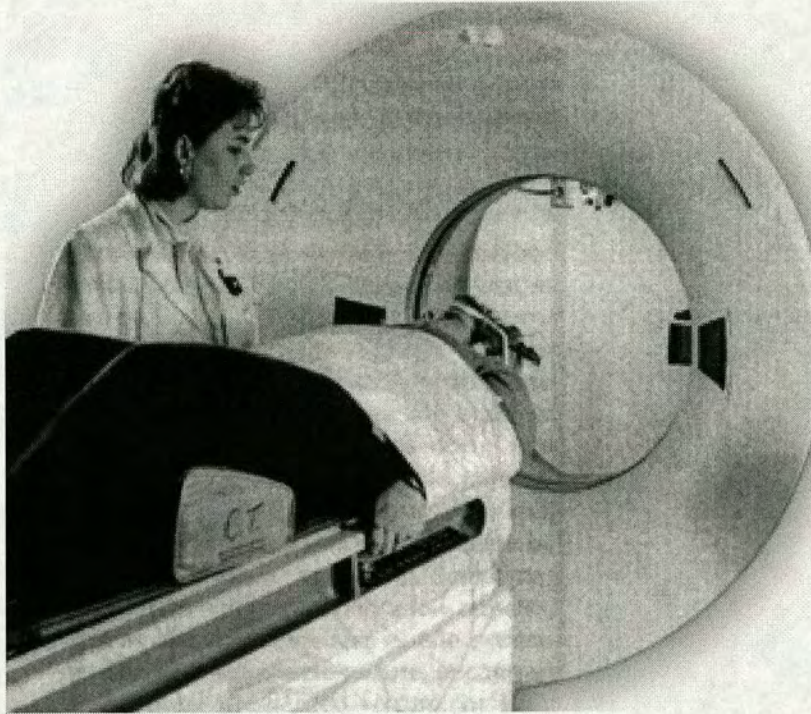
A patient being prepared to enter a typical full-size MRI scanner prior to being imaged.
